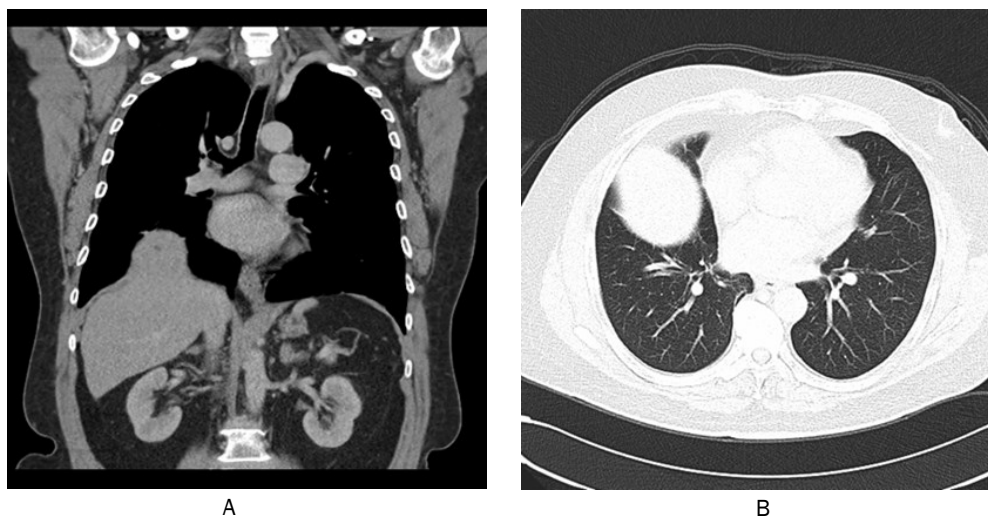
CT thorax coronal view (A) and axial view (B) confirmed an elevation of the anteromedial aspect of right hemidiaphragm with herniation of the liver
